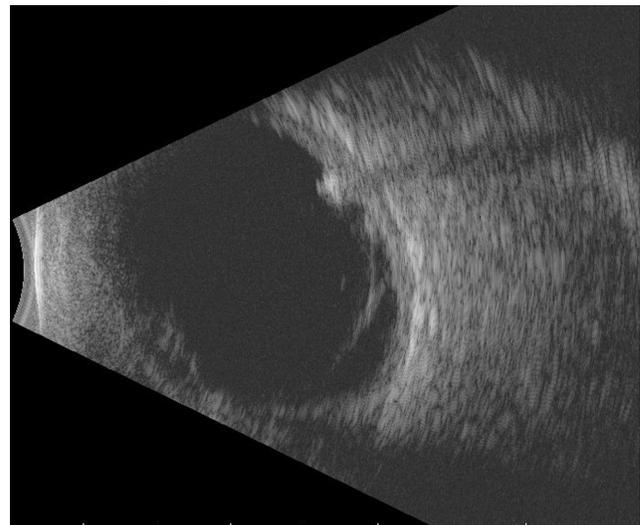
Ultrasound imaging revealed a dense cataract, mild vitreous hemorrhage with a tract-like membrane extending posteriorly, and a highly reflective mobile-appearing opacity lying posteriorly near the optic nerve with shadowing. There was no retinal detachment and no choroidal hemorrhage. The posterior scleral wall was intact. A posterior vitreous detachment was also present.
